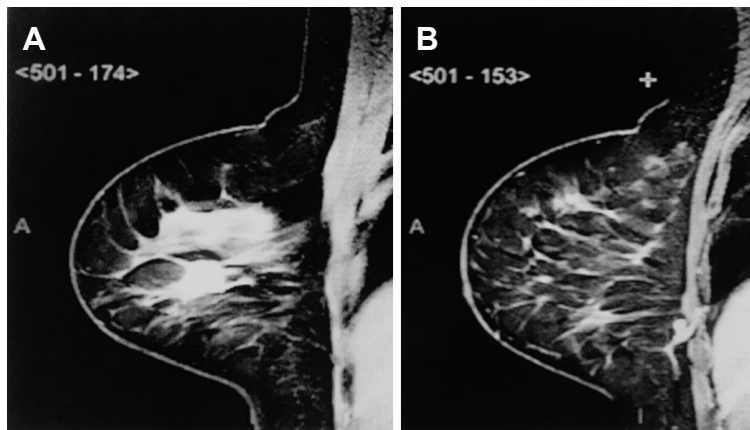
A: Tumor magnetic resonance imaging, axial; B: intramammary sentinel lymph node magnetic resonance imaging, axial view
